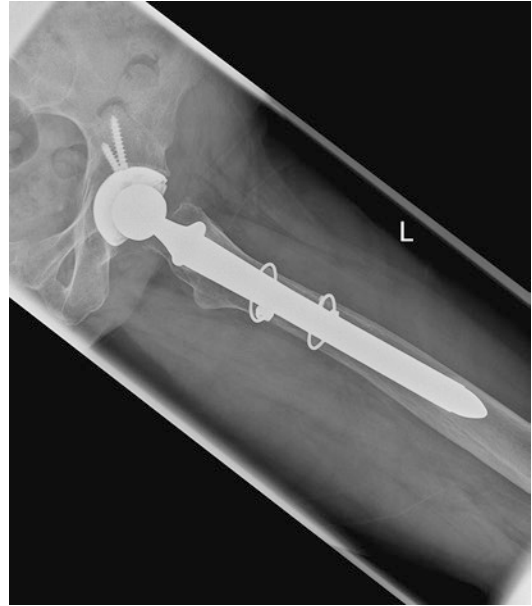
Lateral postoperative X-ray image of the *left hip* following revision of the femoral stem into a diaphyseal engaging stem that bypassed the fracture and provided good distal fixation
